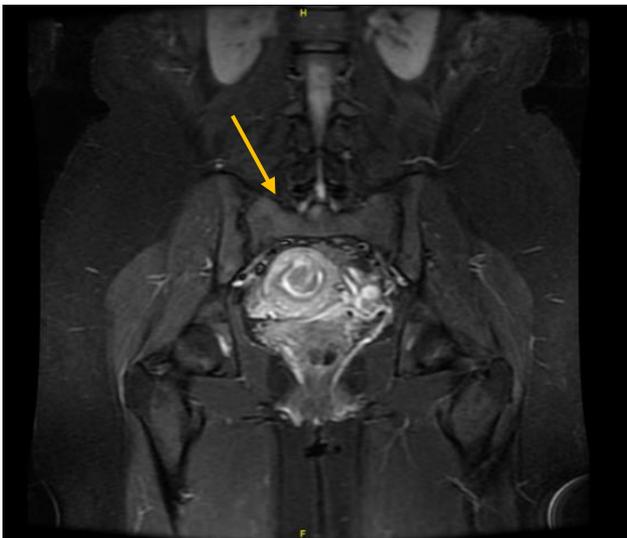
WB-MRI, fat-suppressed T2-weighted sequence pelvic coronal section, mass thickening with irregular contours in the endometrial cavity (yellow arrow).
